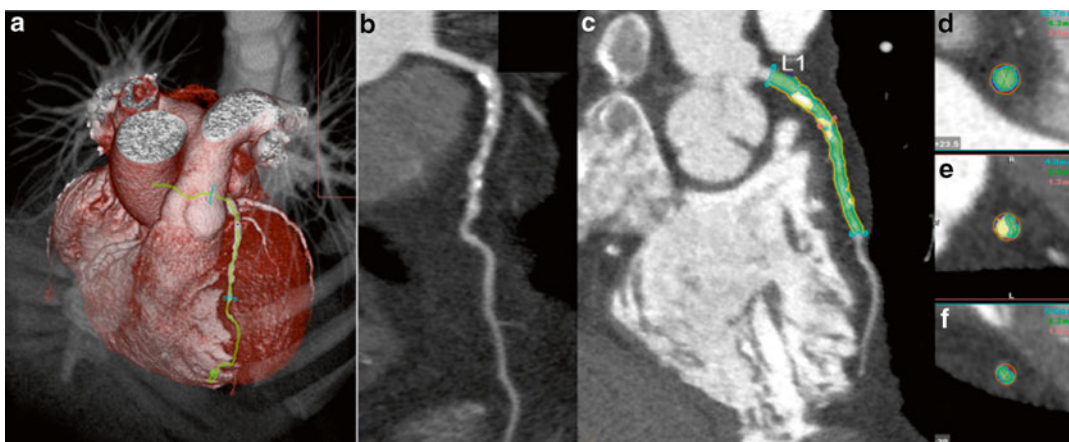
Quantitative plaque assessment using CTA. (a) Volume-rendered image, (b) multiplanar reconstruction showing diffuse severe mixed plaque in left anterior descending artery, (c) quantitative assessment with blue
